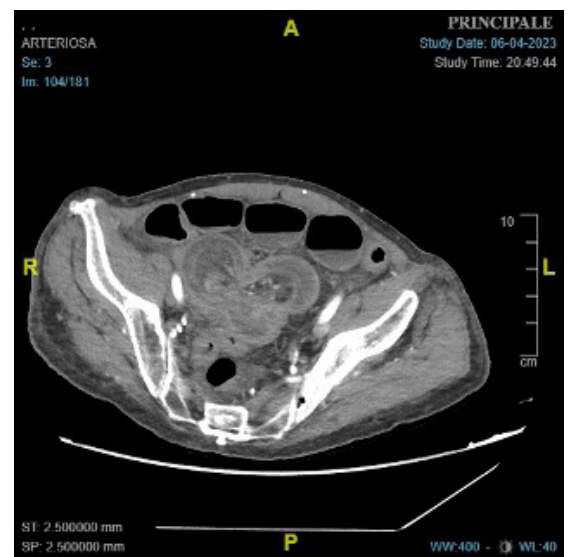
CT scan showing swelling in the proximal jejunoileal loops and no signs of abnormal distension in the colic loops.
